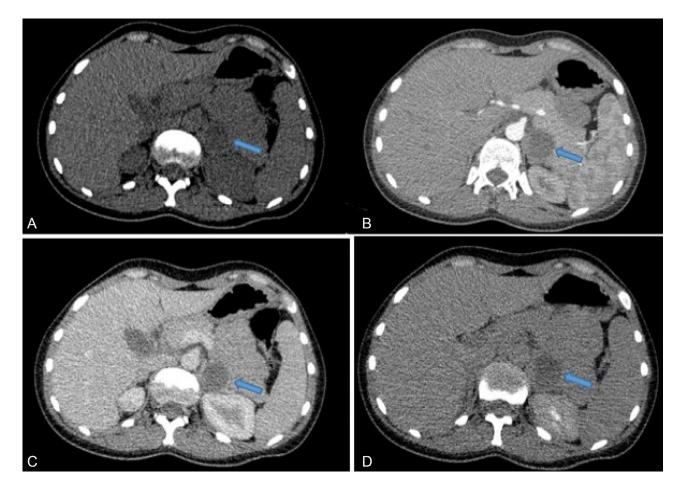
Abdominal CT: axial slices without injection (A) and with contrast agent injection at arterial (B), portal (C), and late (D) phase: hypodense left adrenal mass with non-enhanced fluid density after PDC injection (blue arrow).
